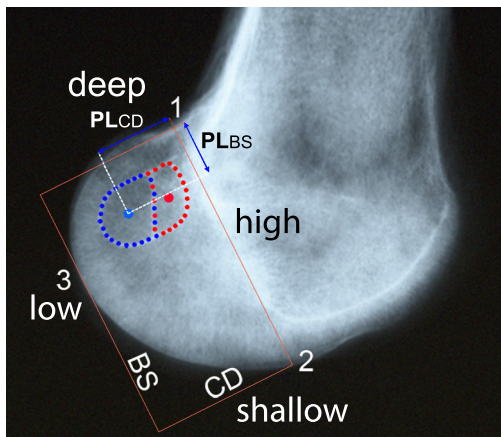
Lateral radiograph with the lines defining the dimensions: Blumensaat's line (BS) between point 1 (deep) and 2 (shallow) and condyle depth (CD) between point 3 (low) and BS (high). The actual centres of the ACL and the AM and PL bundles were defined and its positions relative to BS and CD determined.
